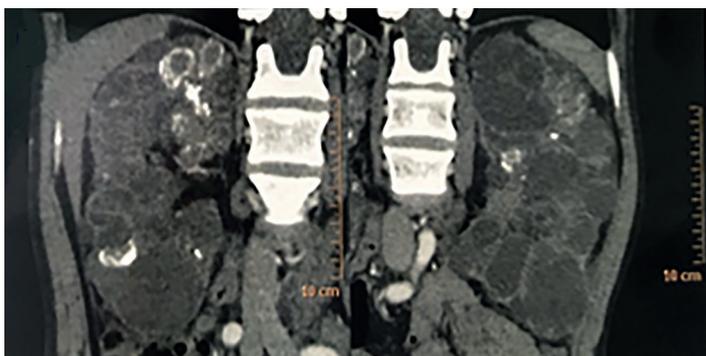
Coronal images of the patient's abdominal CT scan showing enlarged kidneys secondary to the presence of numerous cysts.
